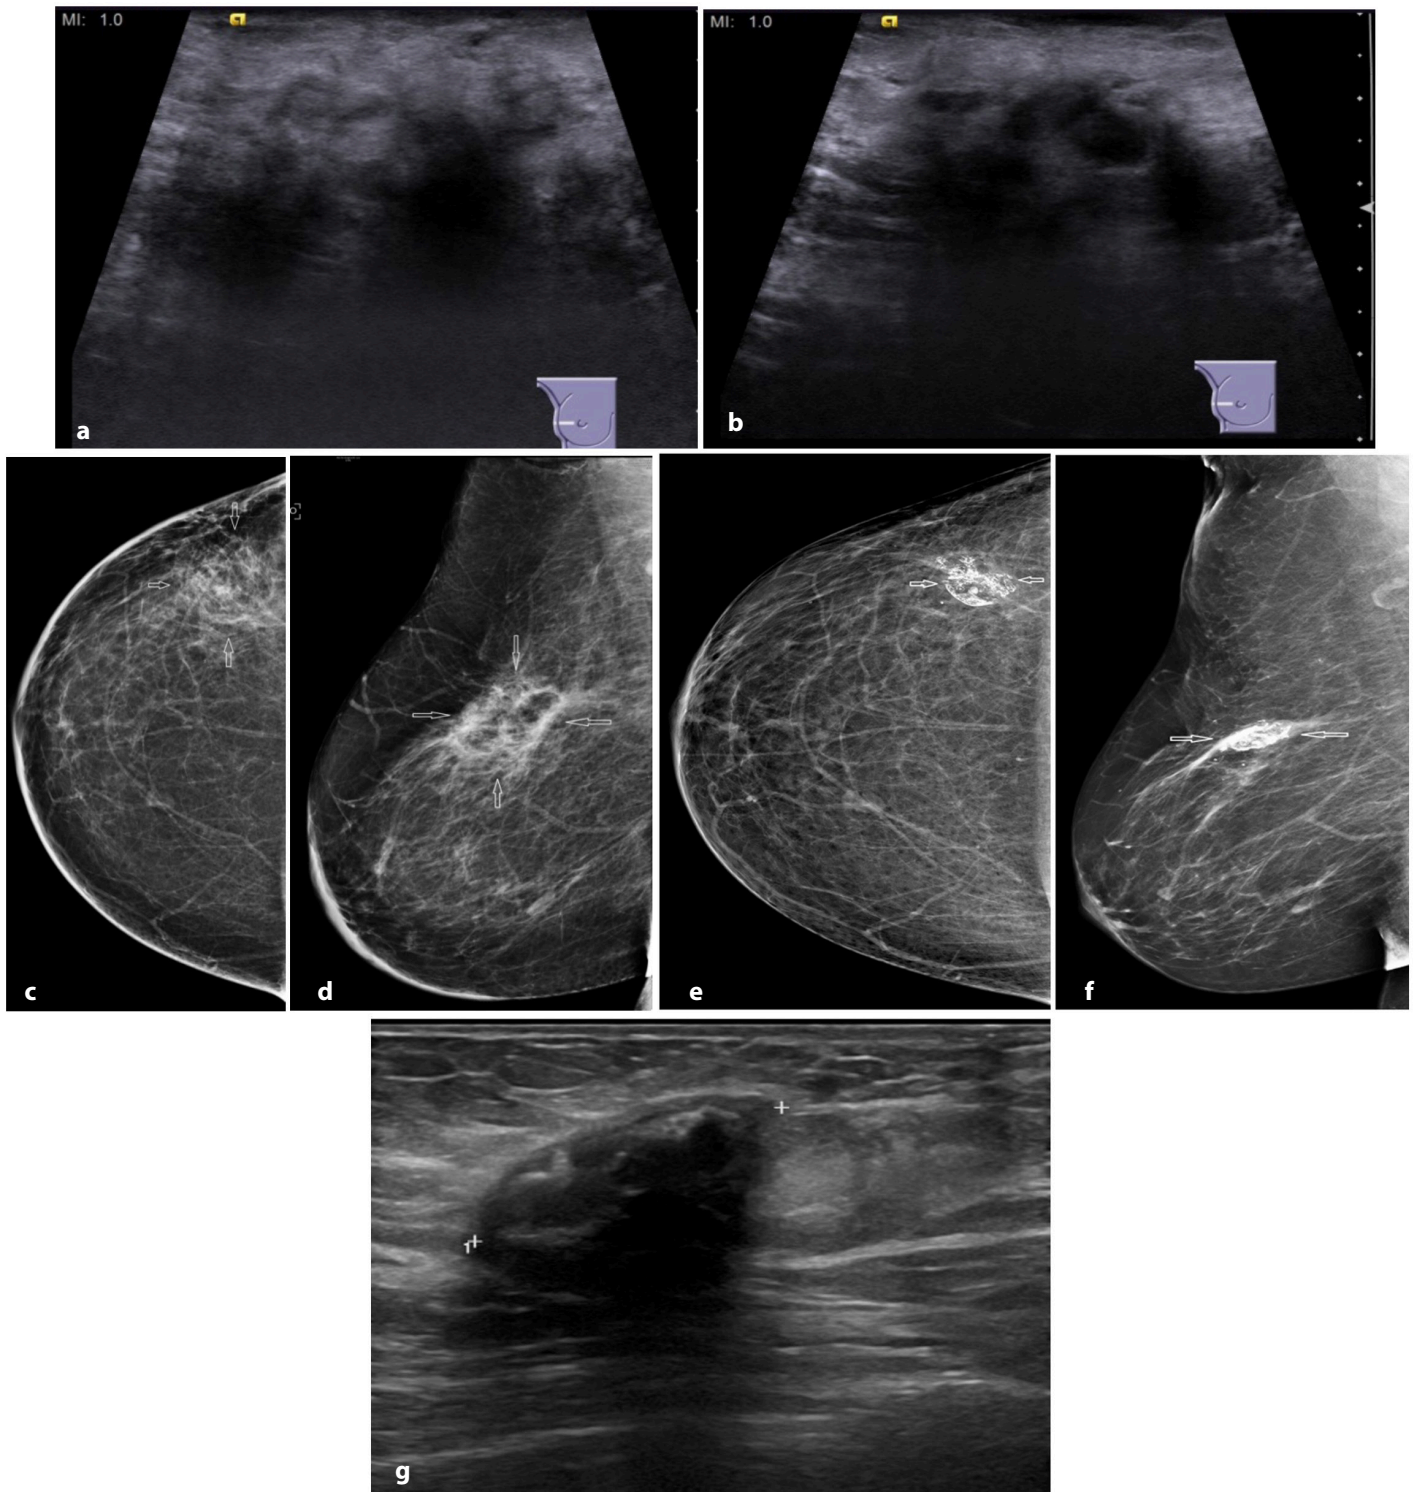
(a-g) US images of a 58-year-old patient treated with IORT, which was taken six months (a) and one year (b) after therapy show a suspicious-looking ill-defined non-mass lesion at the operation site in the right breast. However, mammograms taken at the first follow-up (c, d) show only minor changes compatible with fat necrosis (arrows). Mammograms (e, f) and US image (g) taken five years later show that the lesion turns into a calcified oil cyst on both examinations. IORT, intraoperative radiotherapy; US, ultrasound.
